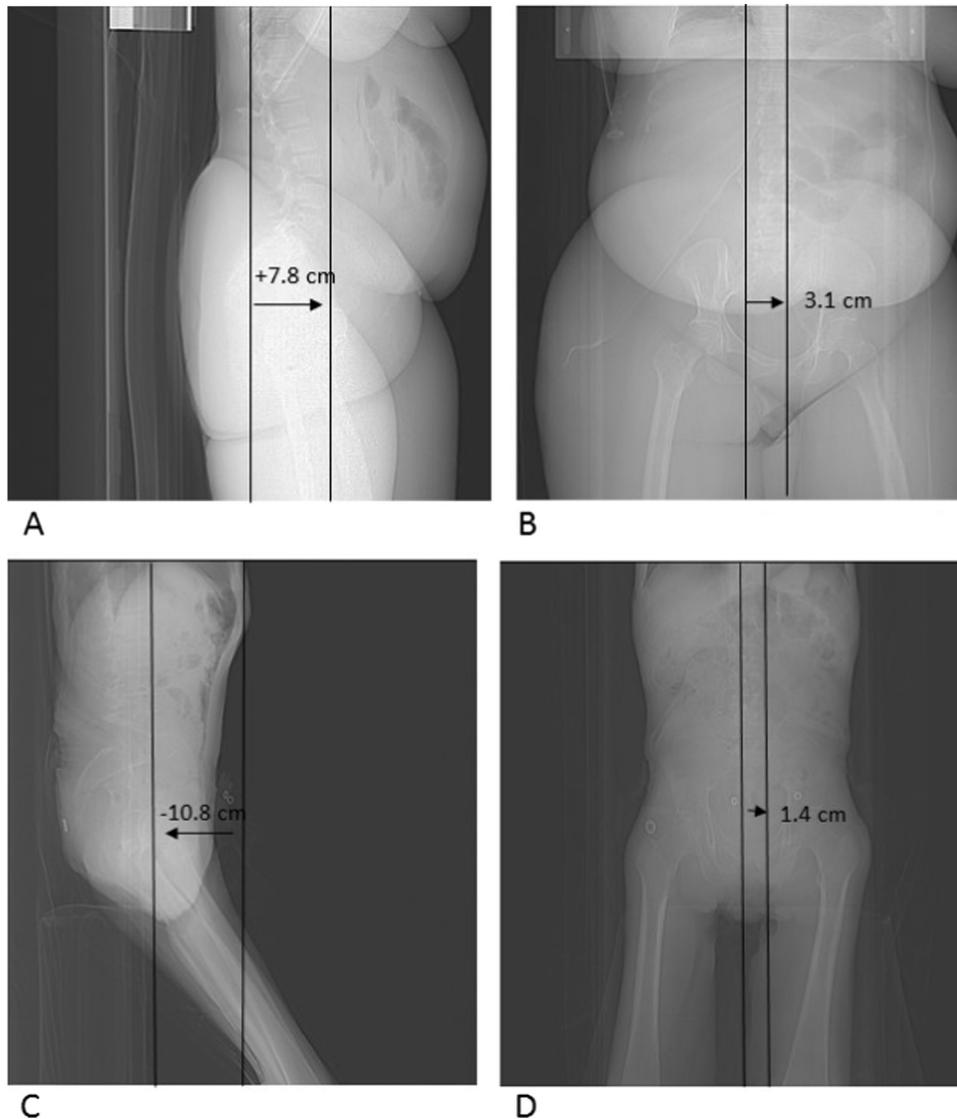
A 43-year-old woman with abdominal distention (A,B), and a 69-year-old man with renal cell carcinoma (C,D). (A,B) Lateral and frontal scout images performed as part of a CT examination. Distances between patient centroid and gantry isocenter: 7.8 cm above center (y-axis), 3.1 cm left of center (x-axis). (C,D) Lateral and frontal scout images performed as part of a CT examination. Distances between patient centroid and gantry isocenter: 10.8 cm below center (y-axis), 1.4 cm left of center (x-axis).
